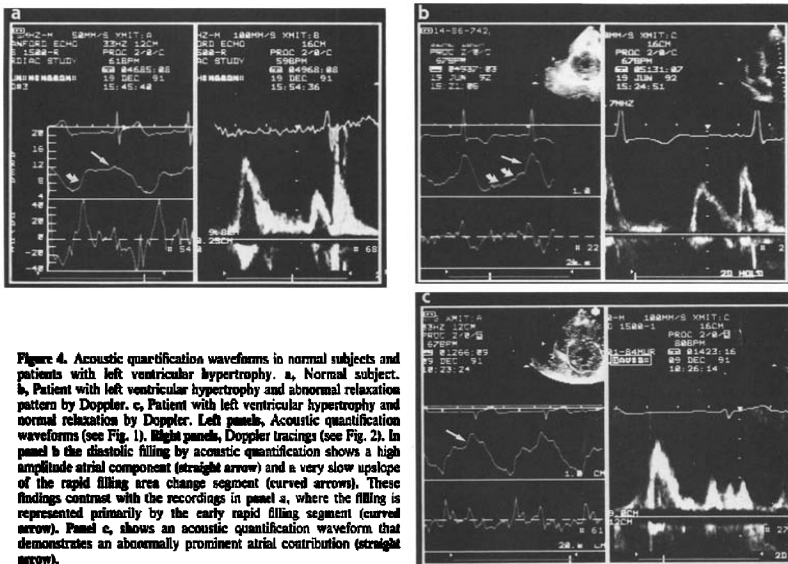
Acoustic quantification waveforms in normal subjects and patients with left ventricular hypertrophy. a, Normal subject. b, Patient with left ventricular hypertrophy and abnormal relaxation pattern by Doppler. c, Patient with left ventricular hypertrophy and normal relaxation by Doppler. Left panels, Acoustic quantification waveforms (see Fig. 1). Right panels, Doppler tracings (see Fig. 2). In panel b the diastolic filling by acoustic quantification shows a high amplitude arial component (straight arrow) and a very slow upslope of the rapid filling area change segment (curved arrows). These findings contrast with the recordings in panel a, where the filling is represented primarily by the early rapid filling segment (curved arrow). Panel c, shows an acoustic quantification waveform that demonstrates an abnormally prominent arial contribution (straight arrow).
